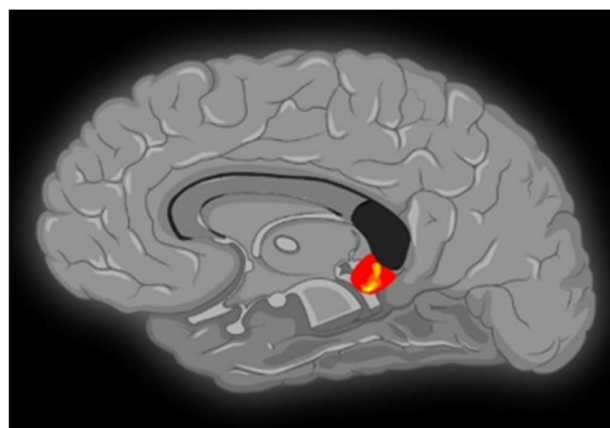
A sagittal MRI sequence is shown, which depicts significant neural activity in the right parahippocampal gyrus.
